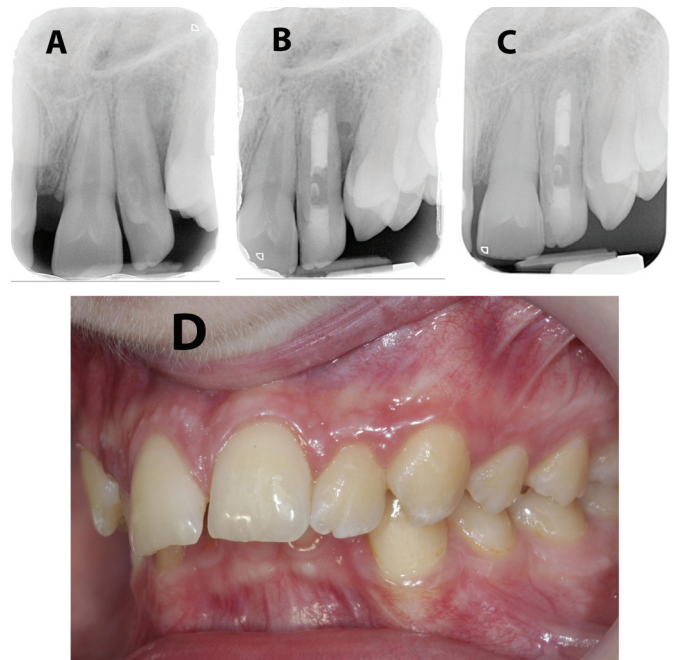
Case 1: Dens invaginatus Class II with an immature, open apex, a potential lateral canal and periapical periodontitis.
